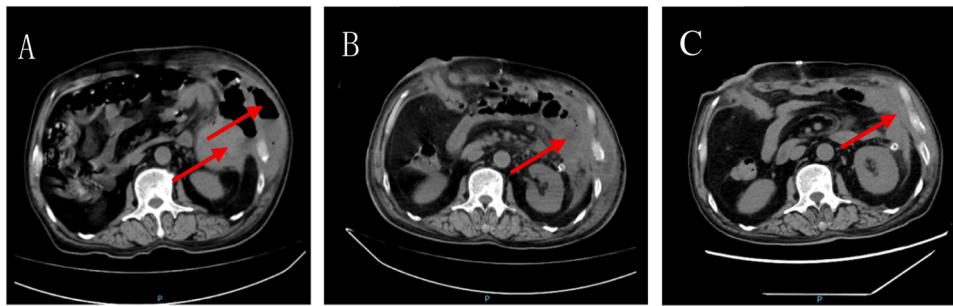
(A) Preoperative CT scan showing a tumor of the descending colon with left abdominal wall swelling, gas and fluid collection, and visible air-fluid levels. (B) Abdominal CT scans performed on day 5 postoperatively revealing the alleviation of the infection and the less pronounced involvement of the abdominal wall and abdominal cavity. (C) Abdominal CT scans performed on day 10 postoperatively showing decreased fluid collection and the resolution of gas accumulation within the abdominal wall.
